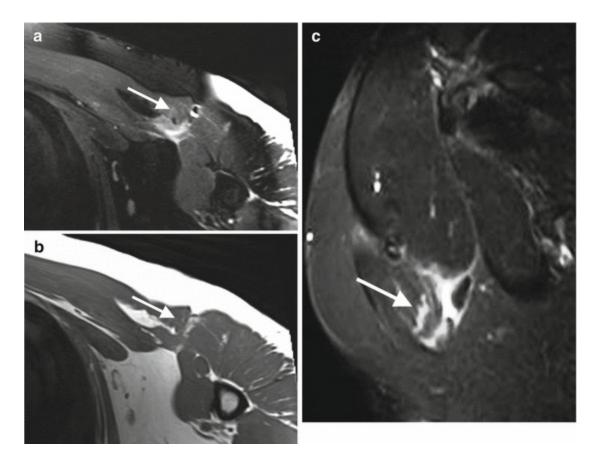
A 39-year-old man with a complete myotendinous junction tear after bench press exercise, 1 week later. Axial fat-suppressed T2-weighted MRI shows a complete distal pectoralis major tear (*arrow*, a). Axial T1-weighted image shows the tendon retracted proximally, superficial to biceps brachii short head and coracobrachialis (*arrow*, b). Sagittal fat-suppressed T2-weighted MRI demonstrates tendon discontinuity in the distal third (*arrow*, c)
